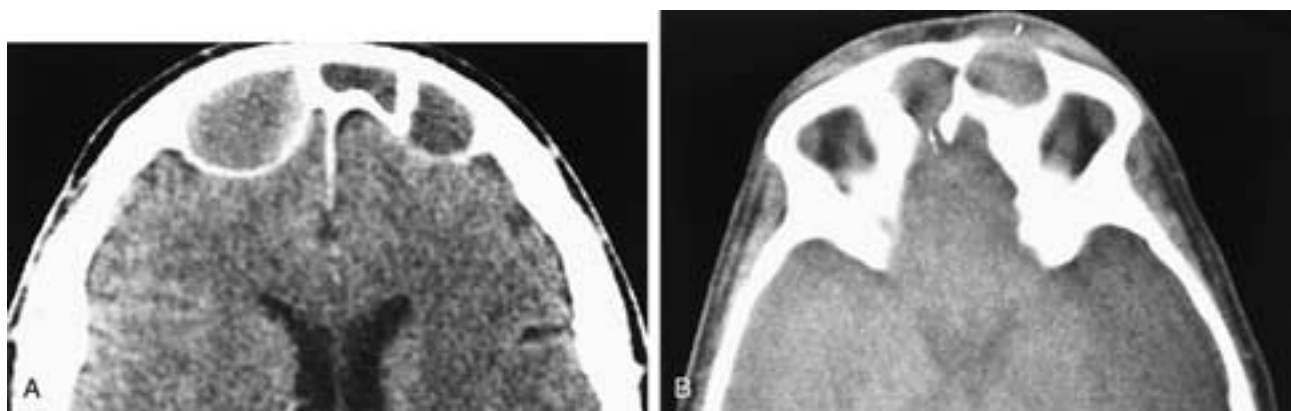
Axial CT scan (A) shows bilateral frontal sinus expansile masses. Each mass has thinned and remodeled the posterior sinus wall, and each mucocoele bulges intracranially. On the plain film, the posterior sinus wall appeared intact. This patient had bilateral frontal sinus mucocoeles. Axial CT scan (B) on another patient shows an expansile mass in each of the left and right frontal sinuses. The left-sided mass has broken through the anterior sinus wall (arrowhead), and the right-sided mass has broken through the posterior sinus wall (arrow). This patient had bilateral frontal sinus mucocoeles.
